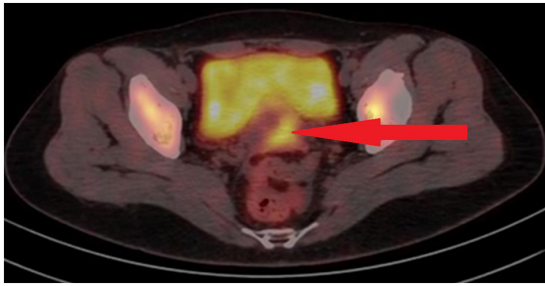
Initial PET-CT image of the cervical region. The cervical metastatic lesion demonstrated notably increased uptake.
